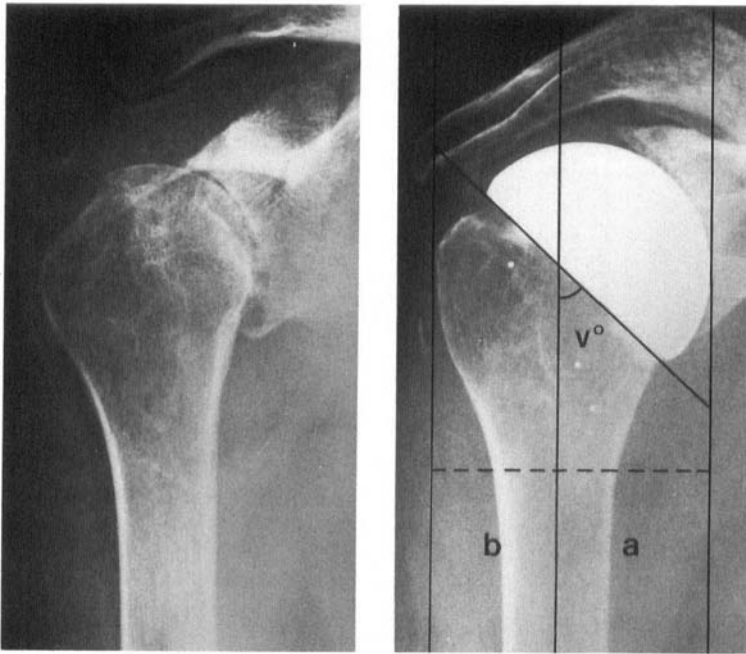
Rheumatoid arthritis before and after arthroplasty. The tantalum balls are used for roentgenstereophotogrammetry.  $a$  = the offset of the cup from the midline of the humerus.  $b$  = the offset of the greater tuberosity.  $v$  = the angle between the base of the cup and the shaft of the humerus.
